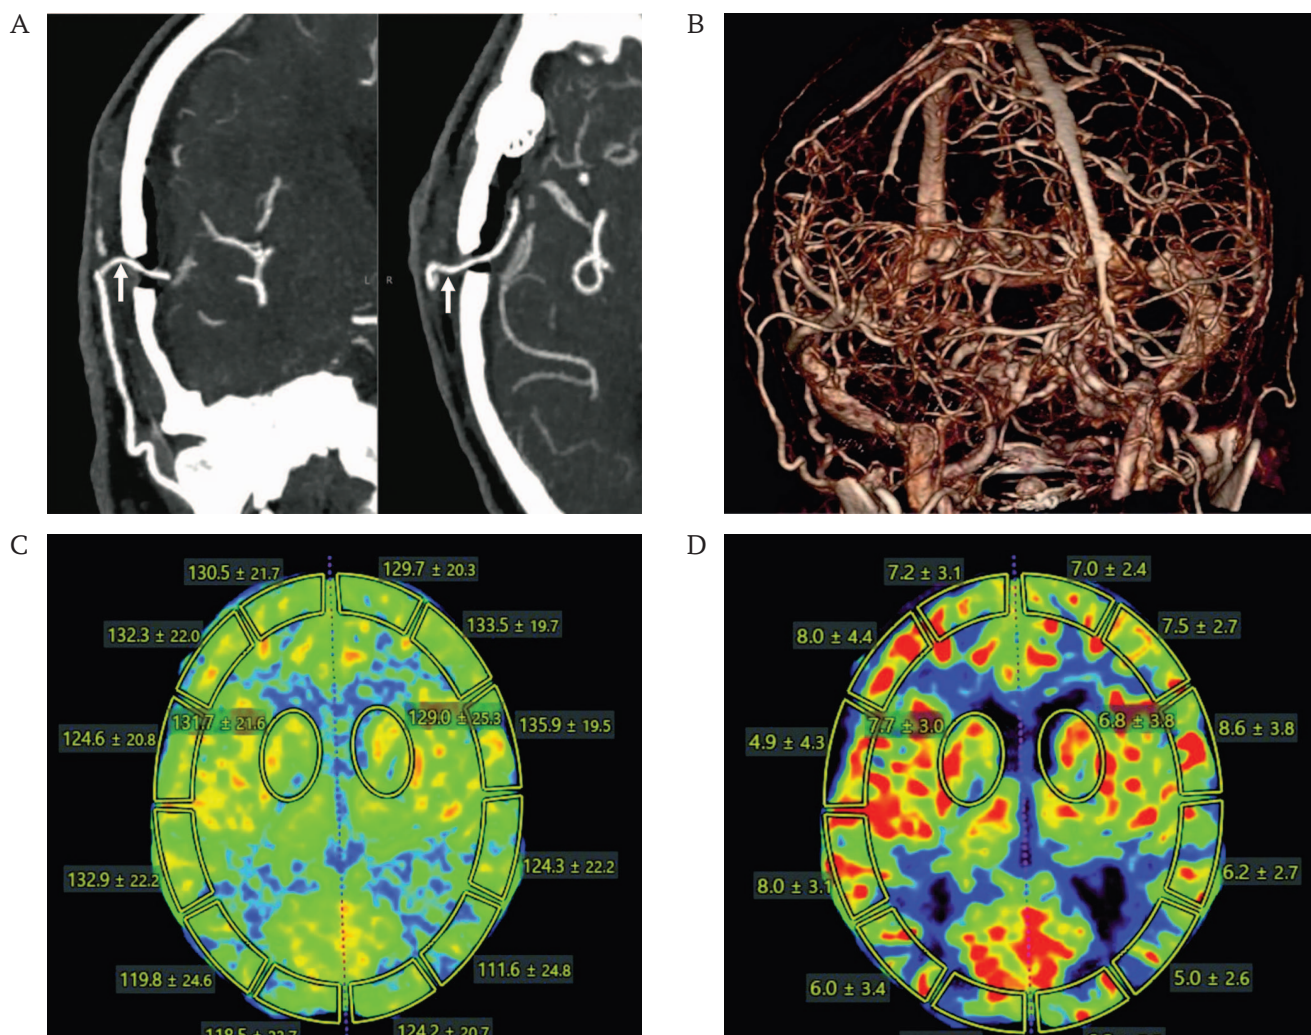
Postoperative computed tomography angiography (A, B) and computed tomography perfusion (C, D) obtained 6 days after surgery.
